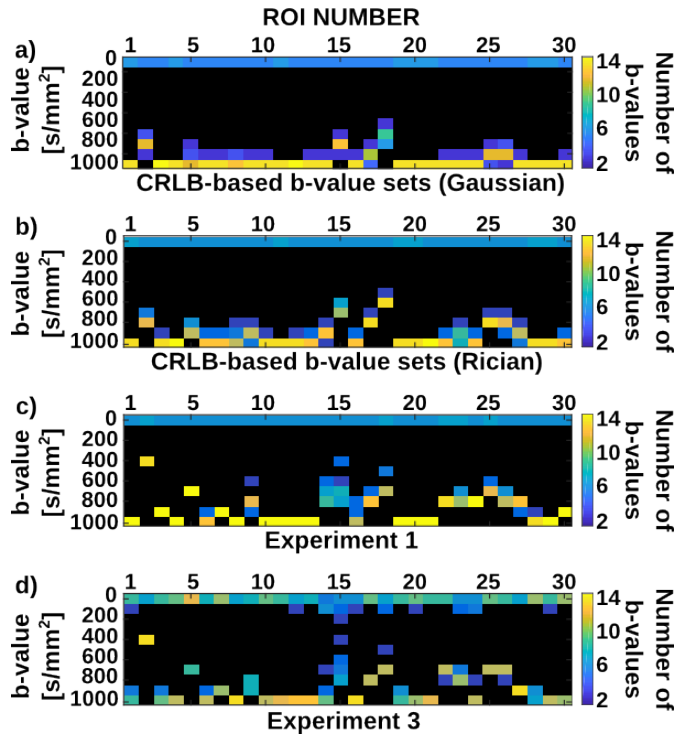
Optimized b-value sets. (a and b) Optimized CRLB-based  $K=16$  b-value sets of the 30 ROIs drawn on the in-vivo liver DWI acquisition. (a) Optimized under a Gaussian noise assumption. (b) Optimized under a Rician noise assumption. (c) Optimized validation sets of  $K=16$  b-values obtained from experiment 1, and (d) experiment 3. Each column shows the optimized set of b-values found for each ROI, where the color code indicates how many times a certain b-value was included in the optimized set. Black background color represents zero number of b-values. Optimizations were performed via the greedy algorithm. Vials characteristics to obtain the CRLB-based b-value sets are given in Table 7.3. There is good agreement between the optimized CRLB-based b-value sets obtained under both noise assumptions and the optimized validation sets of experiments 1 and 3. However, the optimized b-values obtained under the Gaussian noise assumption are higher than those obtained with a Rician assumption, and more differences can be found with respect to the values obtained in experiment 3 (i.e., ROIs 22-27).
